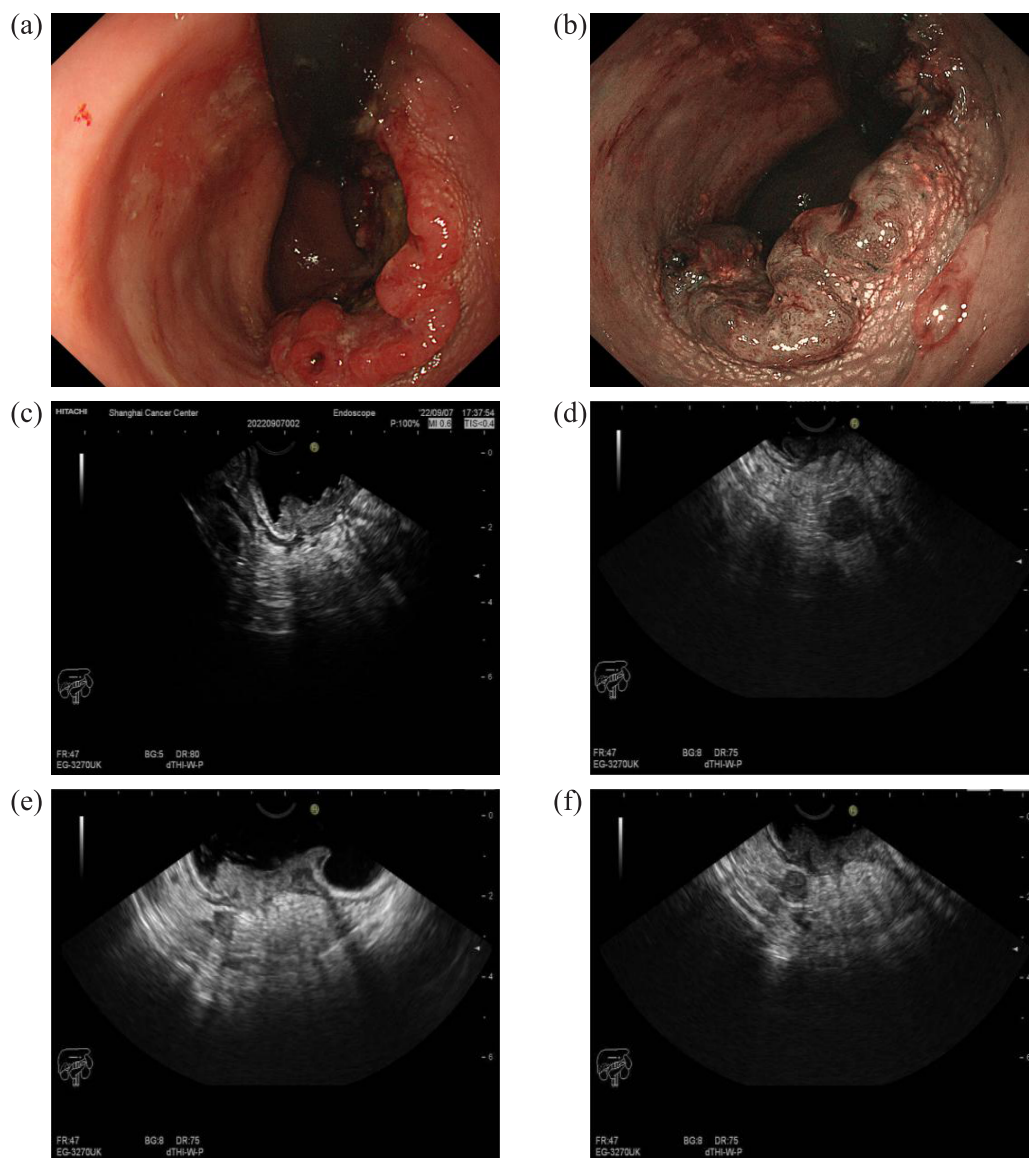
Images from endoscopic ultrasound examinations
